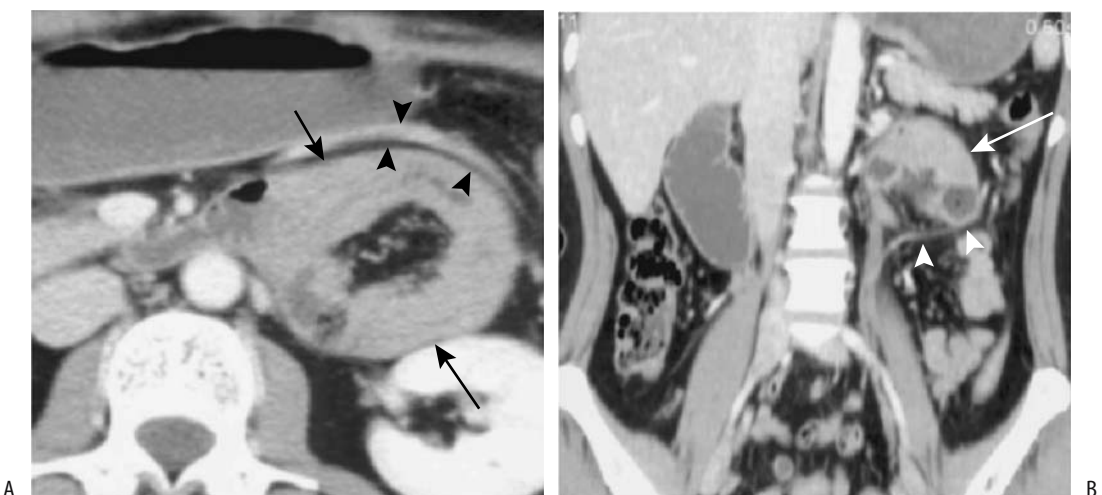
Left paraduodenal hernia. Transverse (A) and coronal (B) postcontrast CT show a small bowel loop within the left paraduodenal region (arrows). The inferior mesenteric vein (arrowheads) is displaced anteriorly and laterally. The central hypodense region in part A represents mesenteric fat. (Source: Okino Y, Kiyosue H, Mori H, et al. Root of the small bowel mesentery: correlative anatomy and CT features of pathologic conditions. *Radiographics* 2001;21:1475–1490, with permission from the Radiological Society of North America.)
